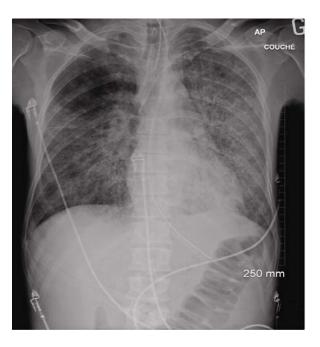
Chest X-ray showing bilateral diffuse interstial infiltrates.
